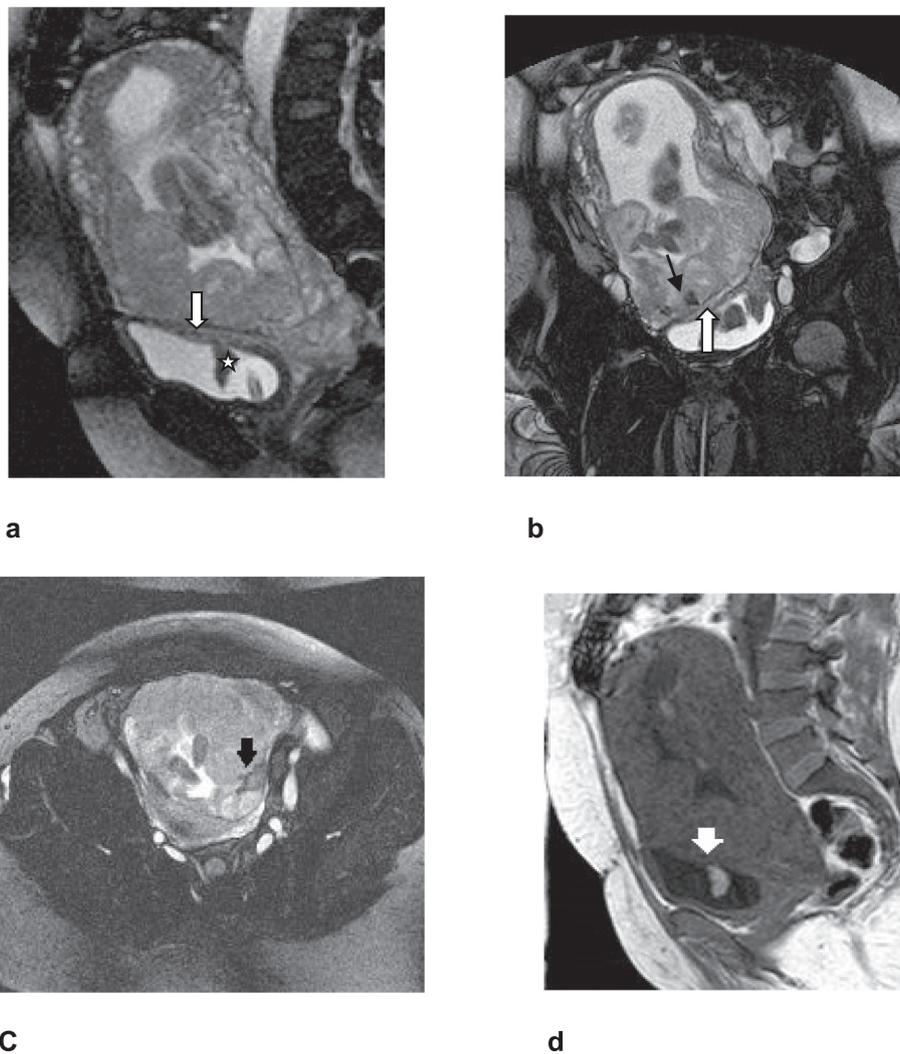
Placenta percreta in a 32-year-old woman (a) sagittal T2-HASTE MRI shows placenta previa centralis with bladder invasion by the placenta at its dome (white arrow) appear as high signal intensity & blood clots inside (white star). (b) Coronal T2-HASTE MRI demonstrates heterogeneous placenta, dark intra-placental bands (black arrow), focal myometrial bulge & interruption (white arrow). (c) Dark intraplacental band (black arrow) also seen in axial T2-HASTE MRI. (d) Obliteration of fat plane between bladder & uterus (white arrow) is better seen in sagittal T1WI.
